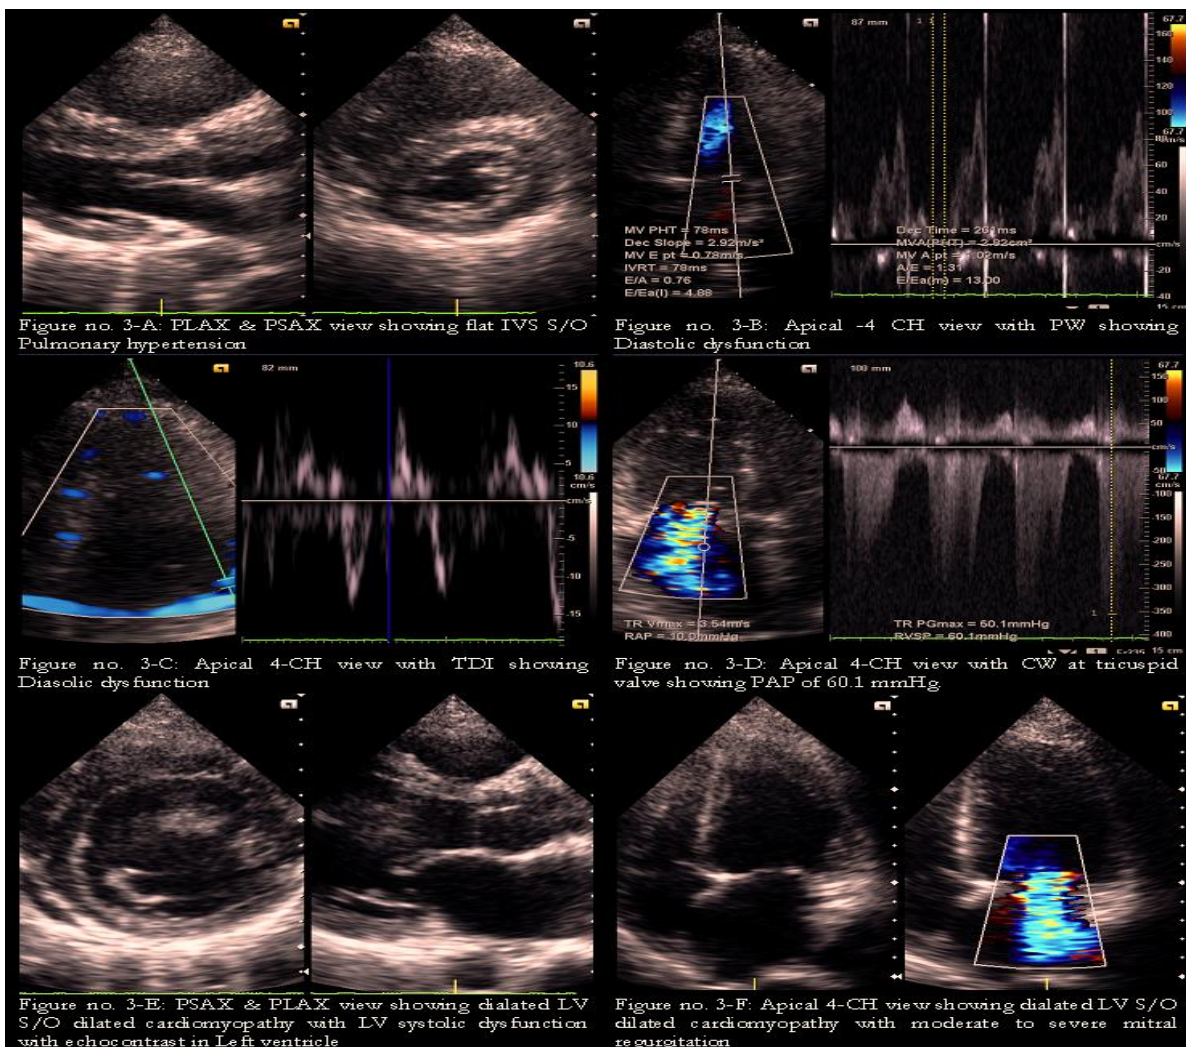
Echocardiographic profile of patients with various cardiorenal syndrome
